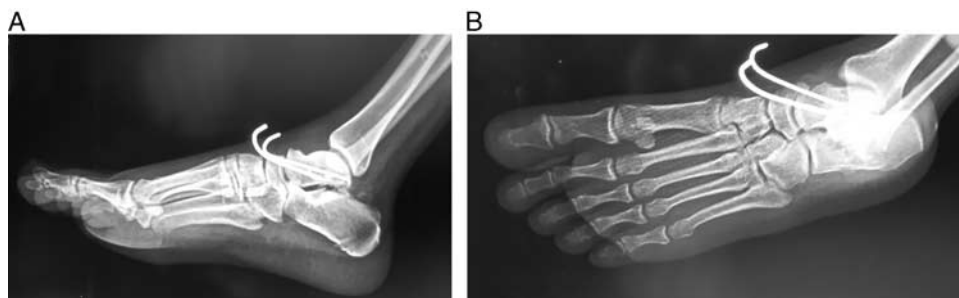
Lateral (A) and oblique (B) radiographs after 1.5 mo.
